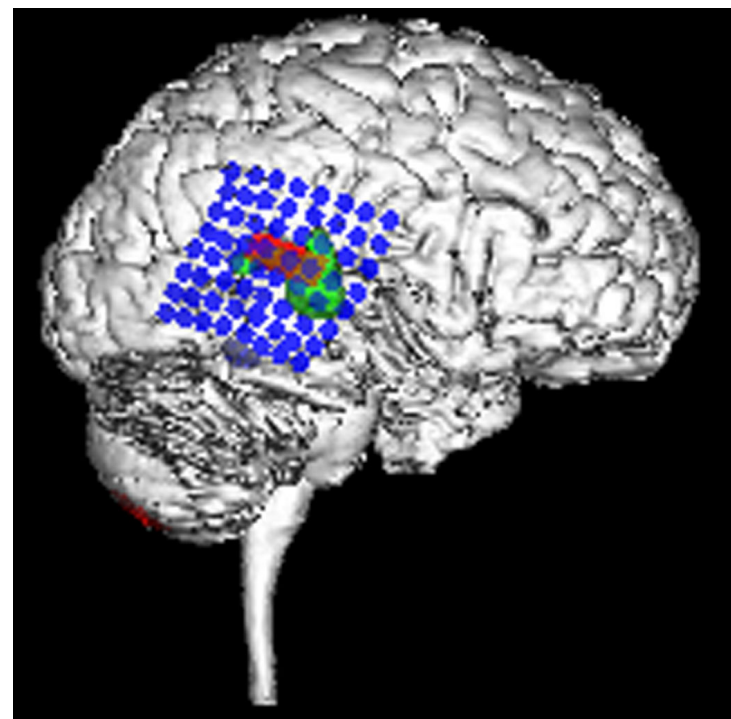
19 year old patient with drug-resistant epilepsy, who underwent anterior 2/3 temporal lobectomy 8 years before without long lasting improvement. Reevaluation with MRI showed postoperative defect but no other focal abnormalities, ictal and interictal EEG did not point to a circumscribed focus. Surface brain rendering with right sided view, SISCOM result (green), intracranial electrode contacts (blue) and ictal onset zone (red). Topectomy of superior temporal gyrus was performed, the patient is free of seizures since operation (12 month).
